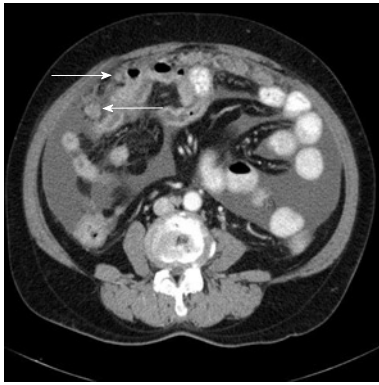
Abdominopelvic computed tomography scan showing ascites and contrast-enhanced peritoneal nodules.
